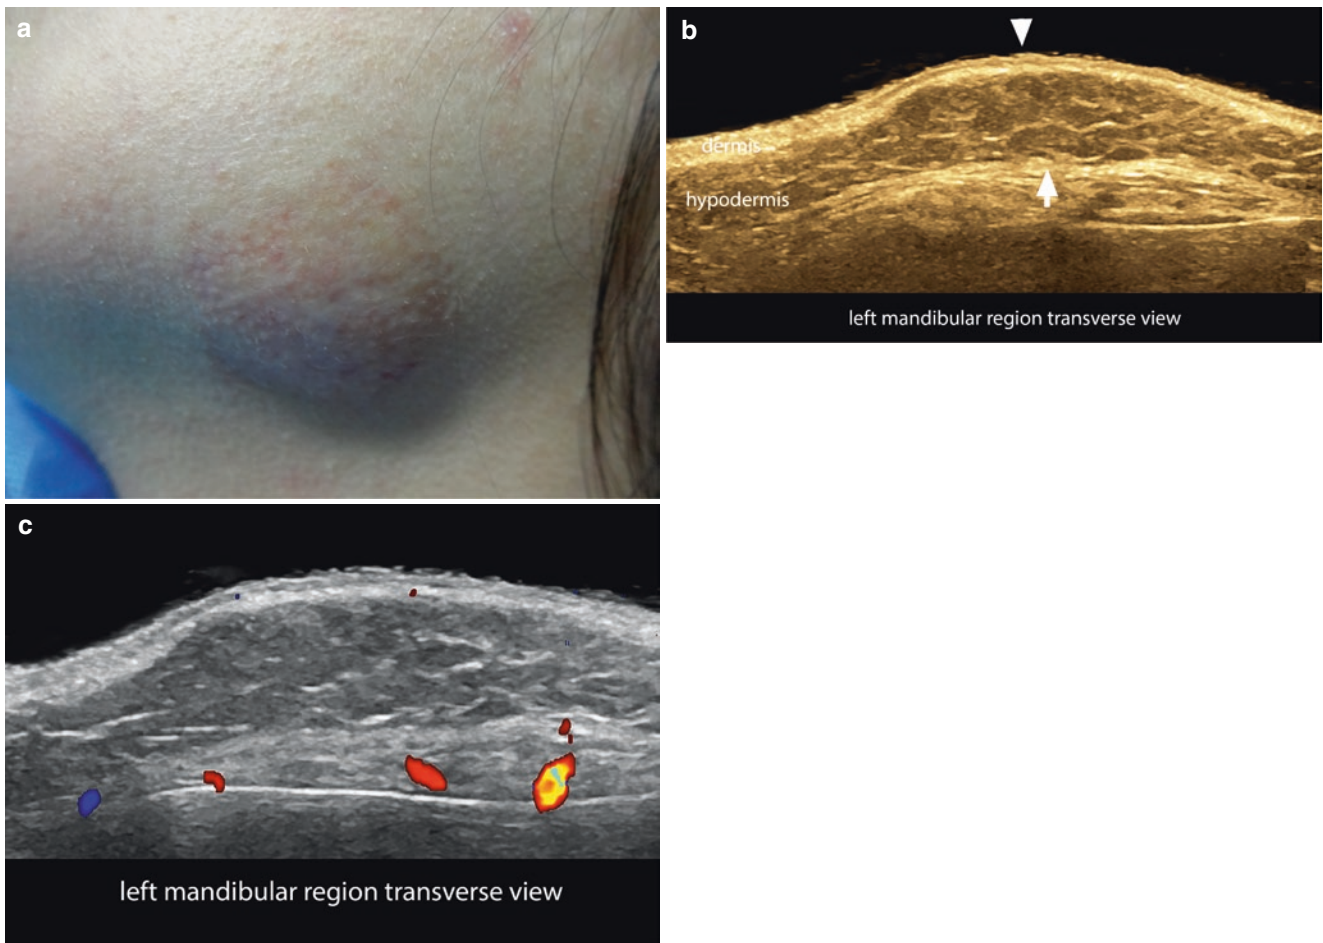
Hemangioma in total regression phase with residual atrophic dermis and a hypertrophic hypodermal lipodystrophy. (a) Clinical image of the lesion in the left mandibular region. (b and c) Greyscale (with color filter) and color Doppler ultrasound (transverse views; left
